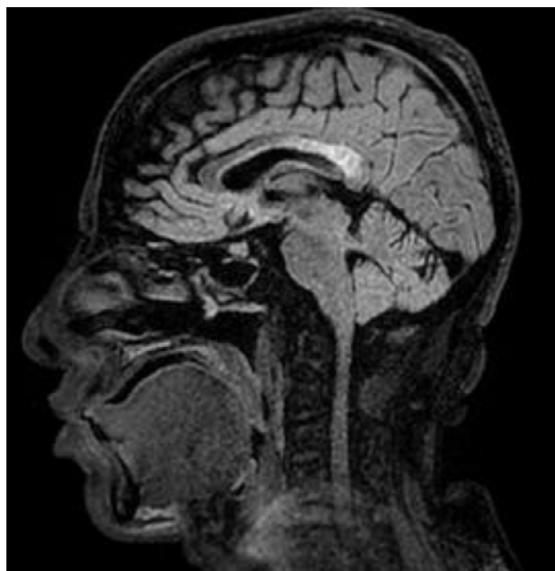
Sagittal FLAIR weighted image demonstrates hyperintense signal in the posterior body and splenium of the corpus callosum.
